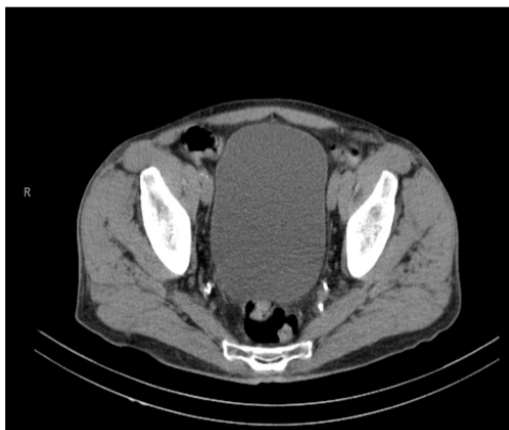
Axial imaging from the repeat CT scan of the pelvis before discharge shows resolution of the surrounding emphysematous bladder wall changes.
